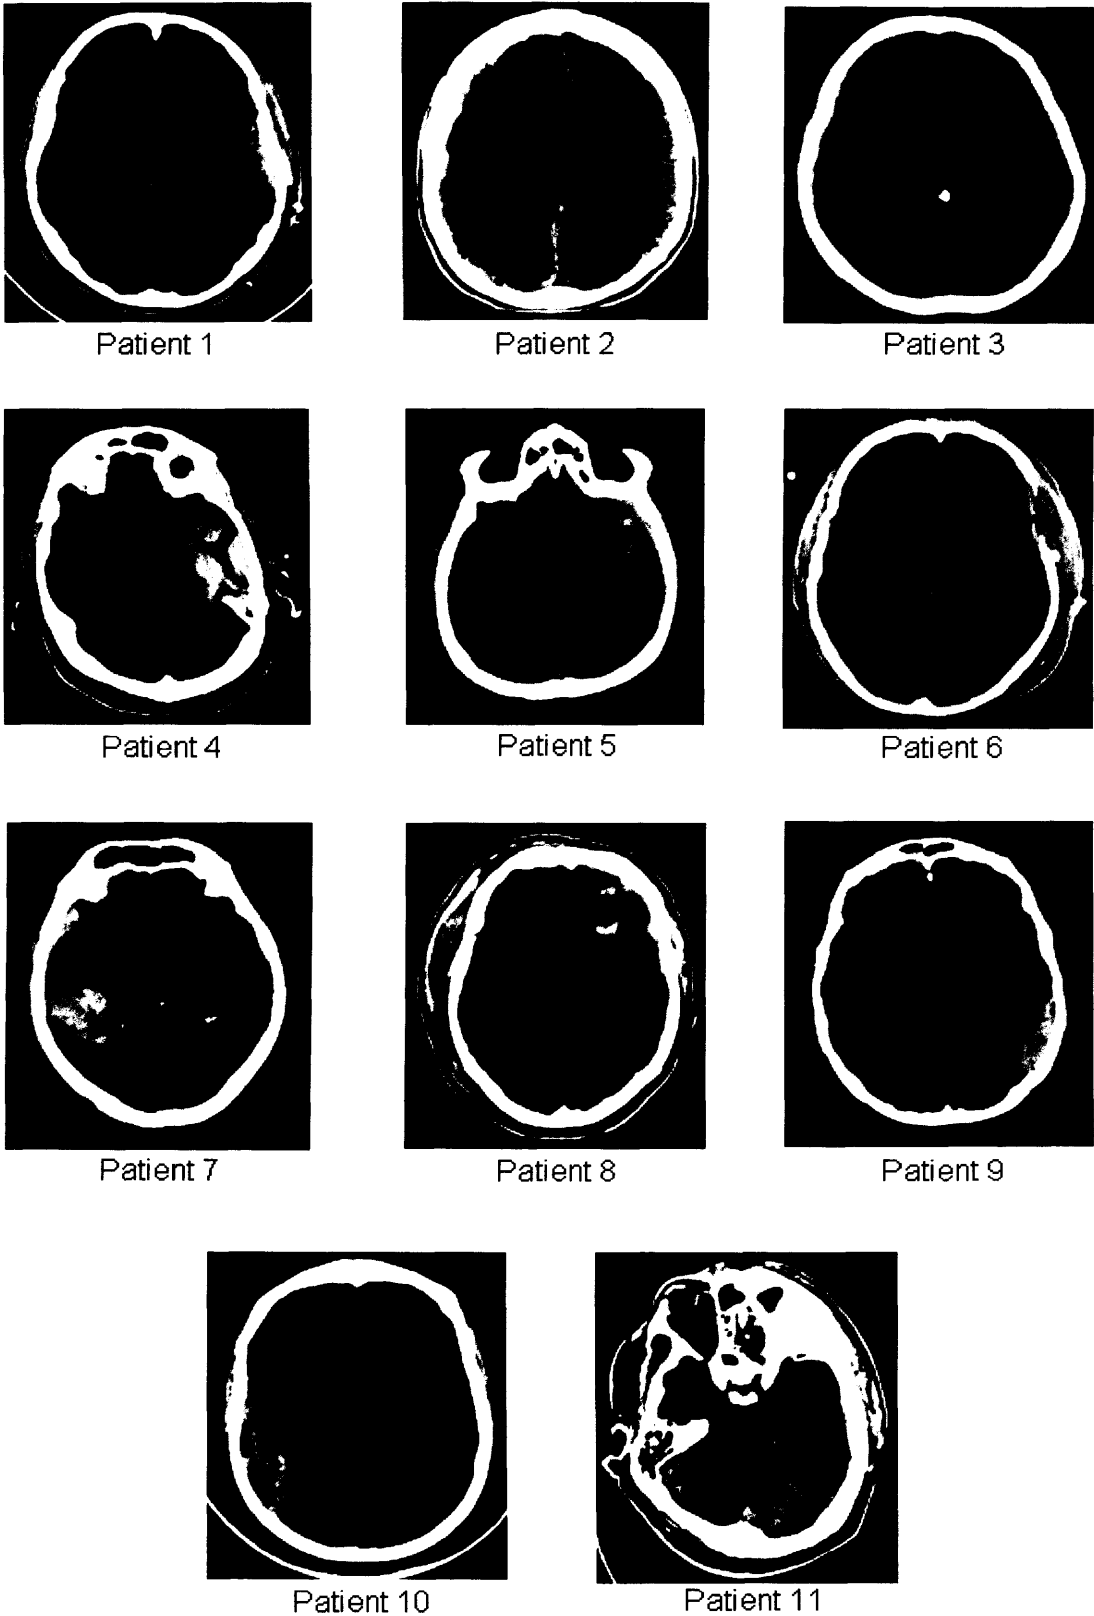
CT scans of patients recruited to study of NBH after TBI.
